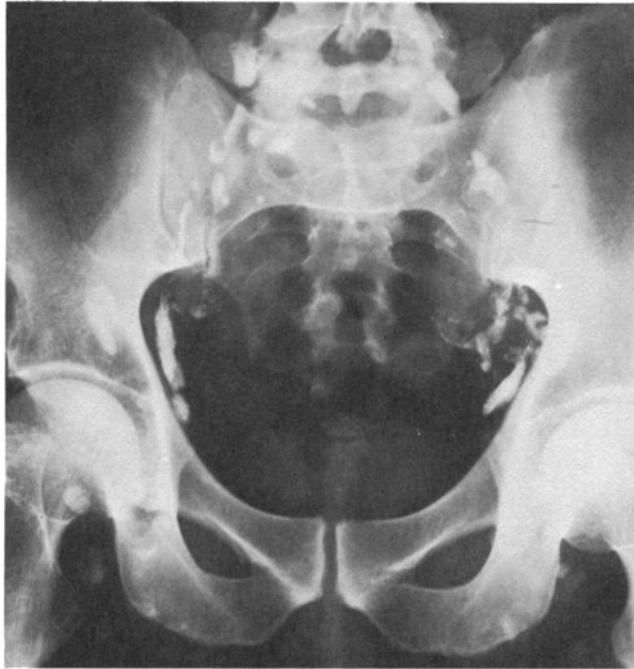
Lymphogram showing an enlarged left external iliac node with an extensive filling defect and classical "egg shell" sign produced by contrast in the subcapsular sinus. The node is also shown on the CT scan. There is probably a right iliac node demonstrated by CT also.
